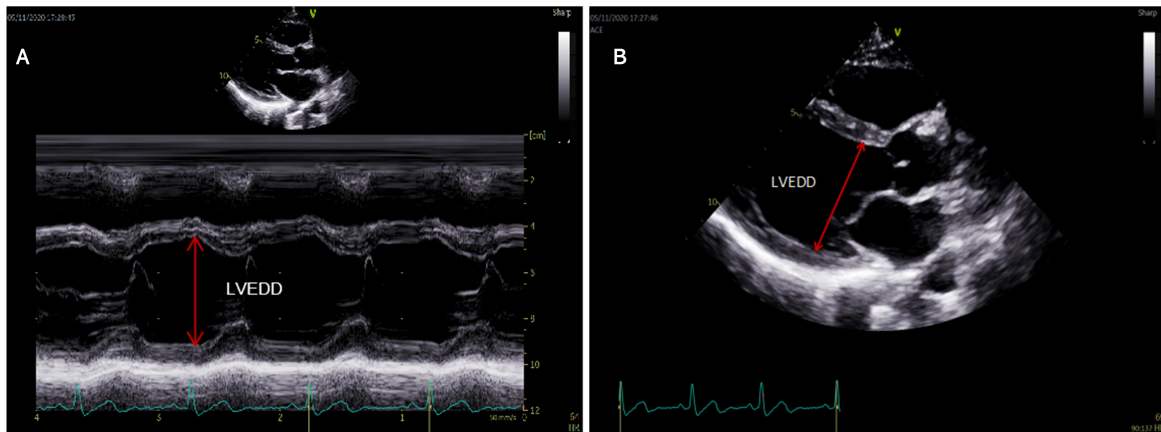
The measurement methods of LVEDD. (A) A motion type scan of the parasternal long-axis in two dimensional views was used to measure LVEDD. (B) In cases where the motion mode cursor could not be aligned perpendicularly to the LV long axis, LVEDD was measured directly on 2D images.
